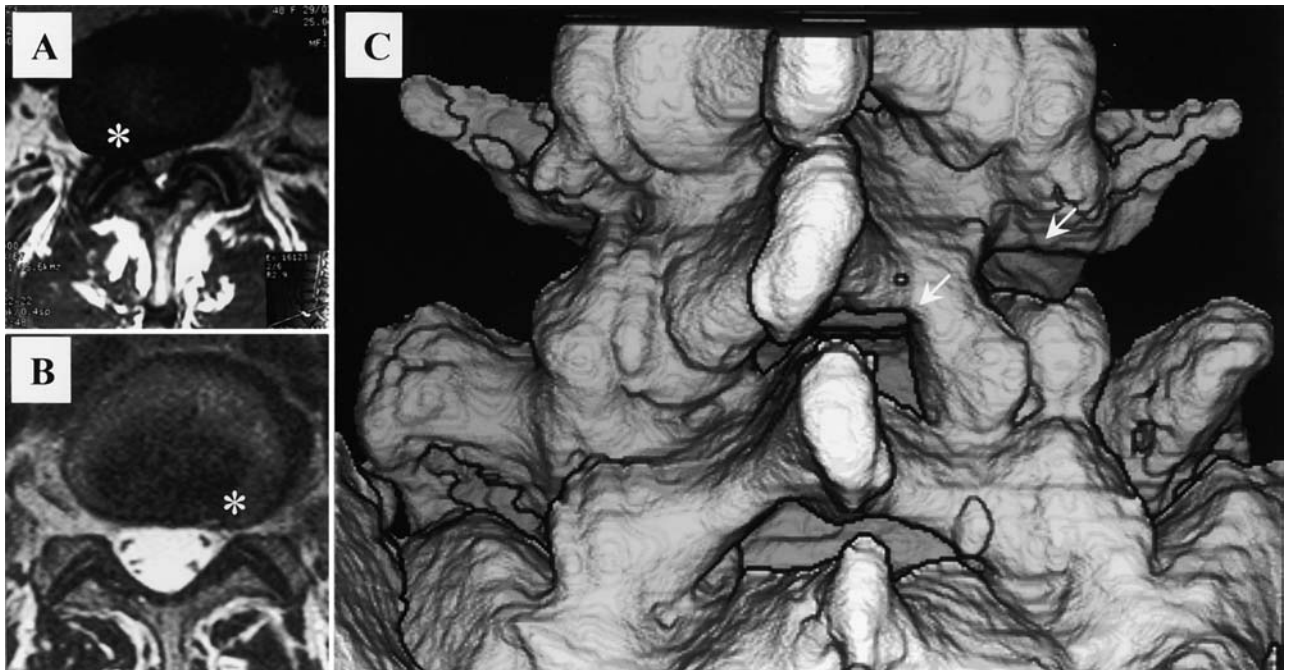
A and B: Preoperative T₁-weighted MR images obtained at level L4–5 on the right side (A) and L5–S1 on the left side (B) revealing a foramen of diminished size and the paucity of perineural fat surrounding the nerve root (*asterisks*). C: Three-dimensional reconstructed CT scans of the lumbar spine obtained 6 weeks postoperatively. *Arrows* indicate L4–5 level on the right. Note preservation of the main portion of the facet joint and the good visual control of the superior and inferior nerve root.
